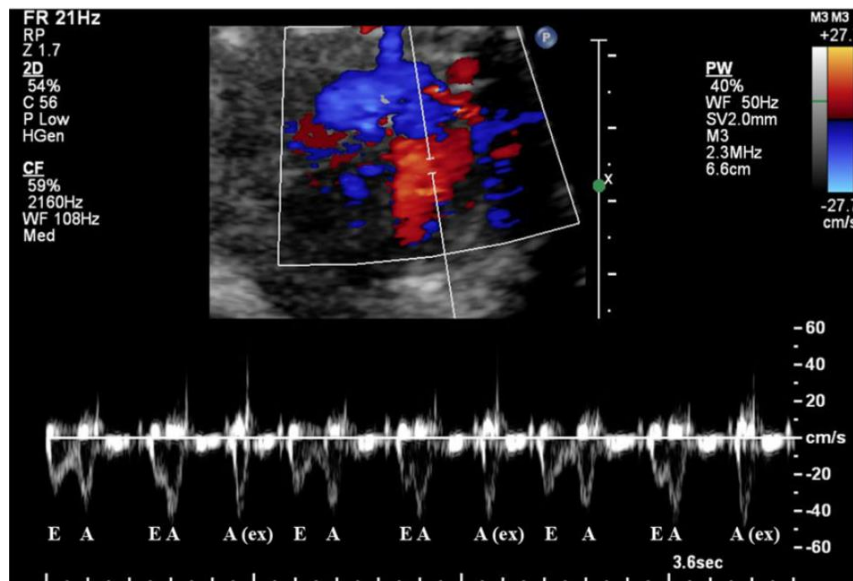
fetal echocardiography, Doppler mode (pulsed wave (PW)), left ventricular inflow pattern.
